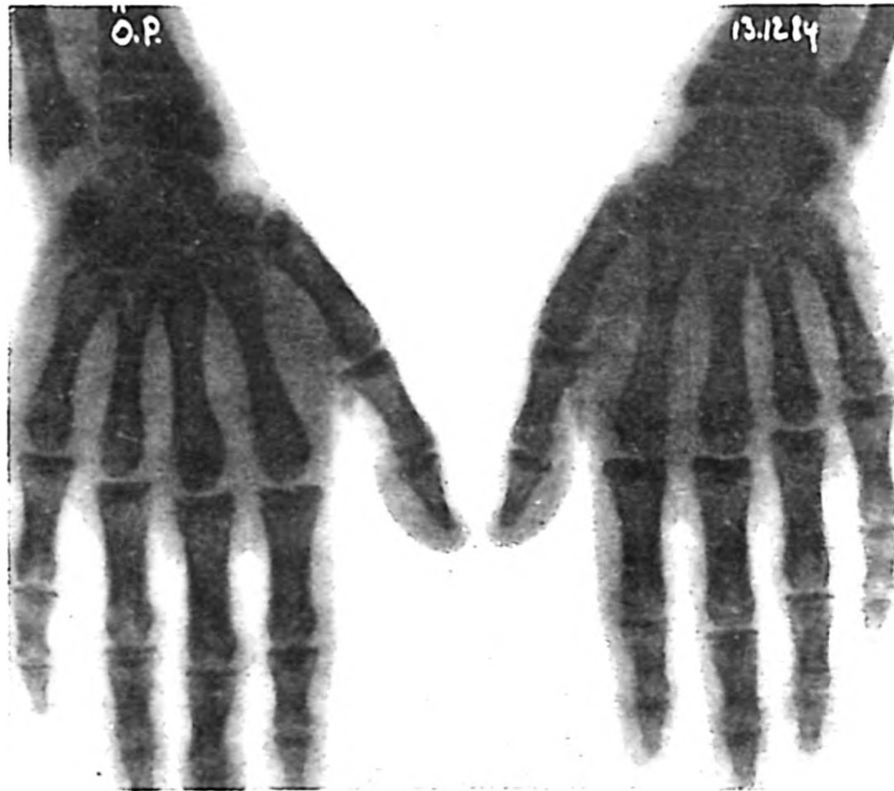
Normal appearance of the hand-wrist roentgenogram.
